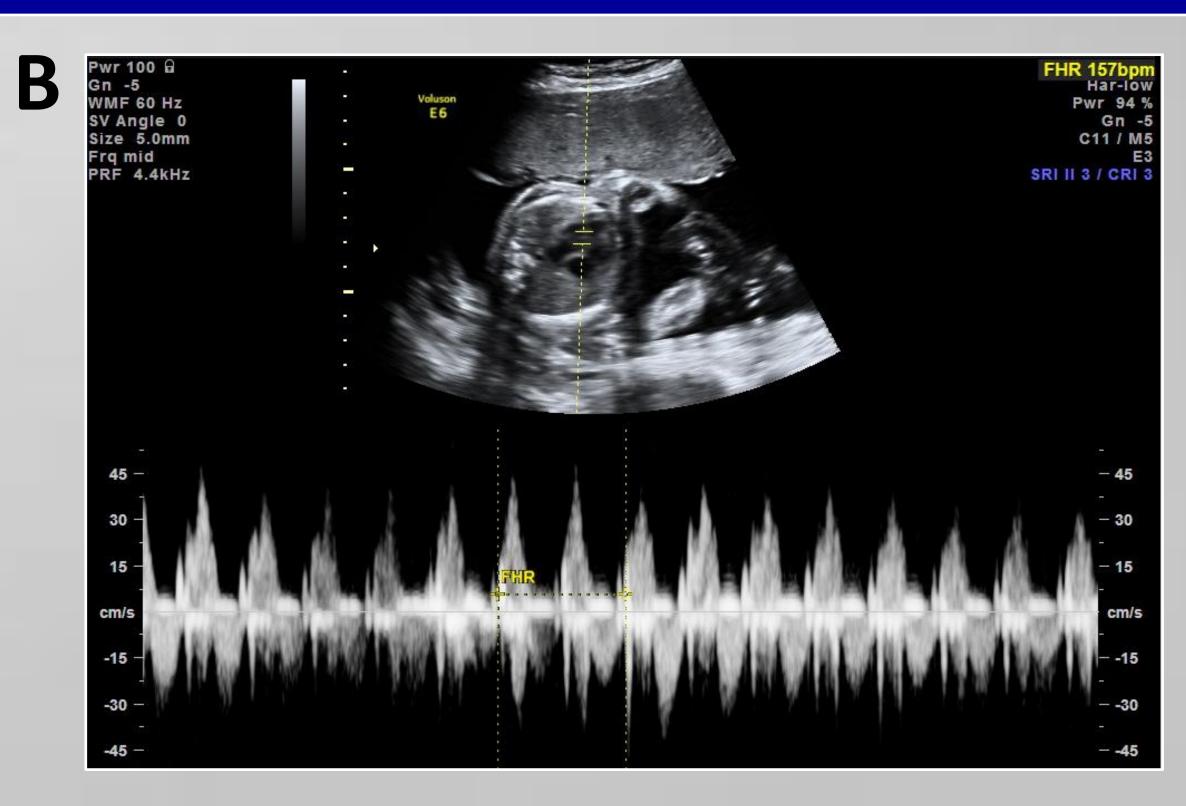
Fetal US at 24 WGA; A:Normal fetal anatomic evaluation. B: Fetal cardiac doppler without alterations.
